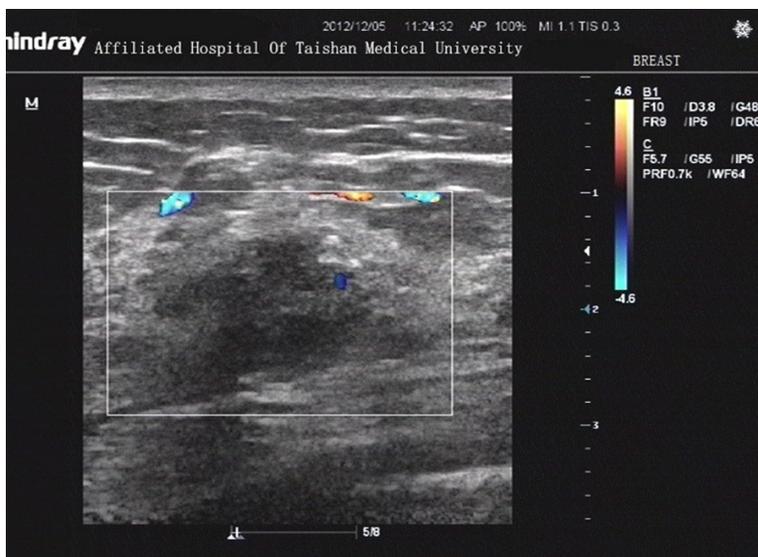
Ultrasound of the breast.
